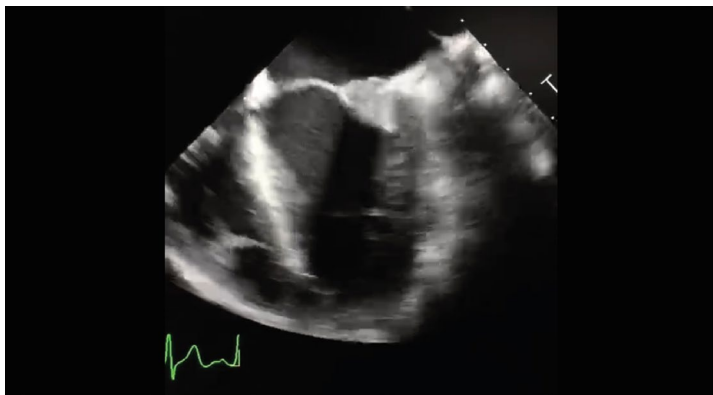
A: Apical window, three chambers showing amorphous image measuring 1.29×0.92 cm on the posterior mitral valve leaflet. B: Long-axis parasternal window showing important mitral regurgitation occupying almost the entire left atrium.
